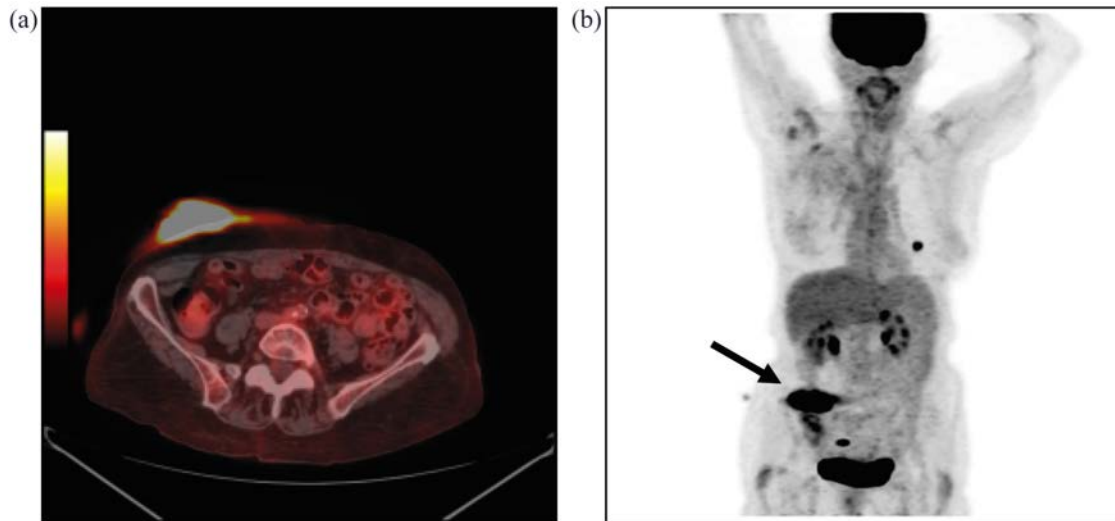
Transaxial fused AC-PET/CT (a) demonstrating extensive tracer contamination of the blanket, which can be falsely interpreted as a malignant uptake in AC-PET images (b) (see arrow). AC: attenuation corrected.
